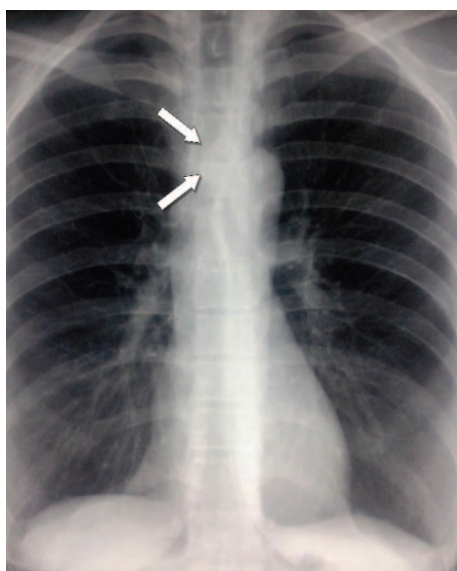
Chest X-ray showing a lesion on the left distal wall of the trachea (arrows).
